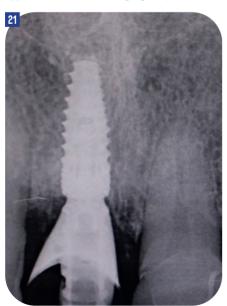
Postoperative radiograph without compressing crestal bone
